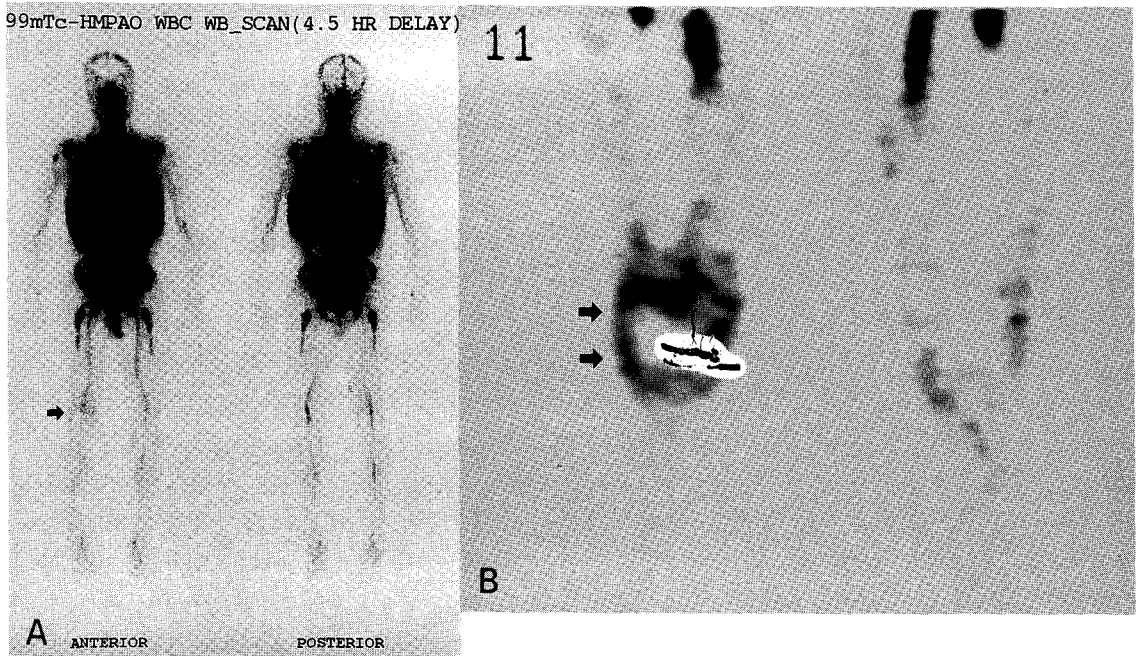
^{99m}Tc -HMPAO leukocyte scintiscan of a 54-year-old man with right knee pain and swelling. He had undergone right total knee replacement arthroplasty 12 years before. (A) The anterior and posterior whole body planar images show mild and diffuse uptake (grade IIa) around the femoral component of the knee prosthesis (arrow). (B) Periprosthetic uptake is better clarified on coronal SPECT image than planar image (arrows). Aseptic loosening was confirmed by surgery.
